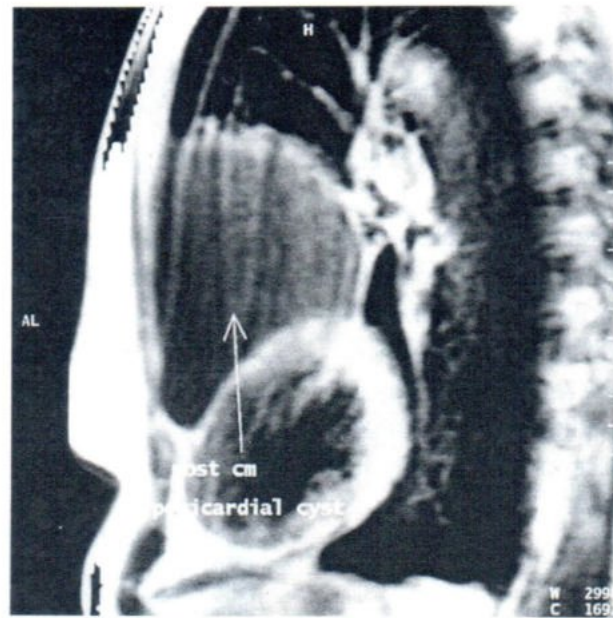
Axial post-contrast CT scan demonstrates right middle lobe bronchiectasis and anterior pericardial cyst.
